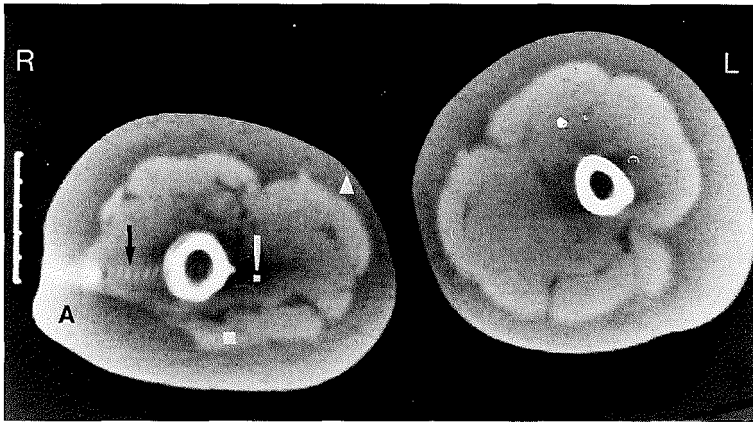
CT scan at the level of a proximal fixation pin inserted on the lateral side (right femur).
